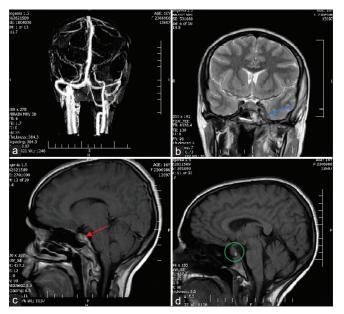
Unremarkable magnetic resonance (MR) venogram of the brain, with no evidence of venous sinus thrombosis (a). Coronal T2-weighted brain MR image depicts an asymmetrically expanded left cavernous sinus (blue arrow) (b). Precontrast sagittal T1-weighted brain MR image shows signal hyperintensity due to blood collection within the pituitary gland (red arrow) (c). Precontrast sagittal T1-weighted brain MR image demonstrates an approximately 15 mm \times 20 mm sellar lesion without compression of the optic chiasm (green circle) (d)
